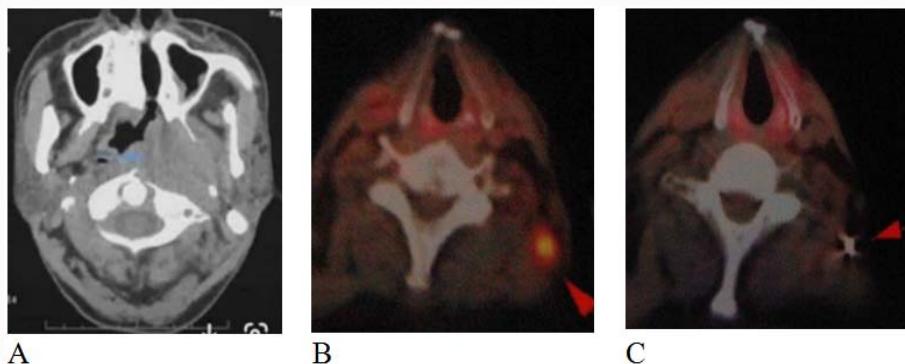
The imaging findings of Case 10. A: CT showed neoplasms in the nasopharynx; B: 4 years later, PET-CT showed enlarged lymph nodes in the anterior neck with enhanced activity (arrow points); C: PET-CT follow-up after one year of TTV treatment showed that metastatic lymph nodes had lost activity (arrow pointing).
